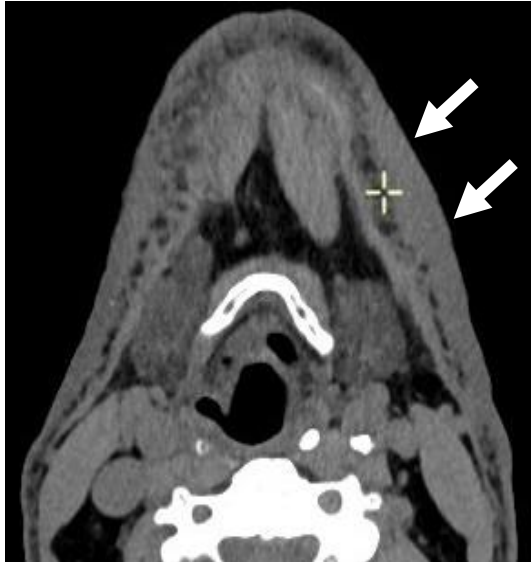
CT scan with contrast of the head and neck region. Thickening of the tissues (skin, subcutaneous tissue, fascia and platysma muscle) of the left cervical region (arrows).
